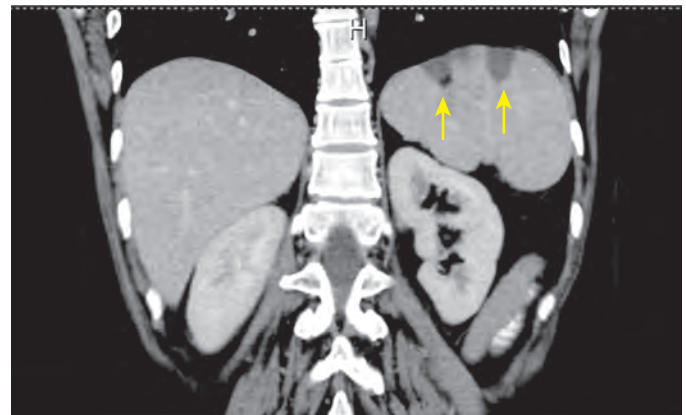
Splenic infarcts: CT findings. Coronal reformatted CT image shows two low-density regions (arrows) within the superior aspect of the spleen in this patient with atrial fibrillation.
